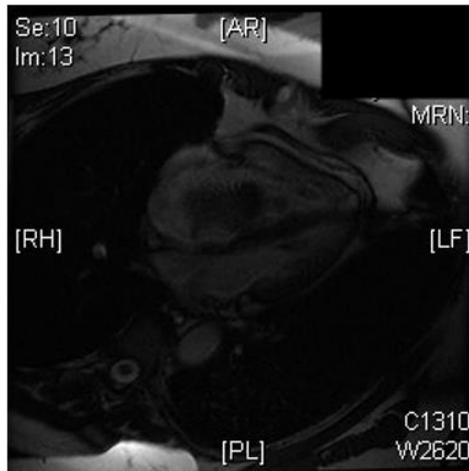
Cardiac magnetic resonance imaging demonstrates intracardiac mass crossing the plane of tricuspid valve.
